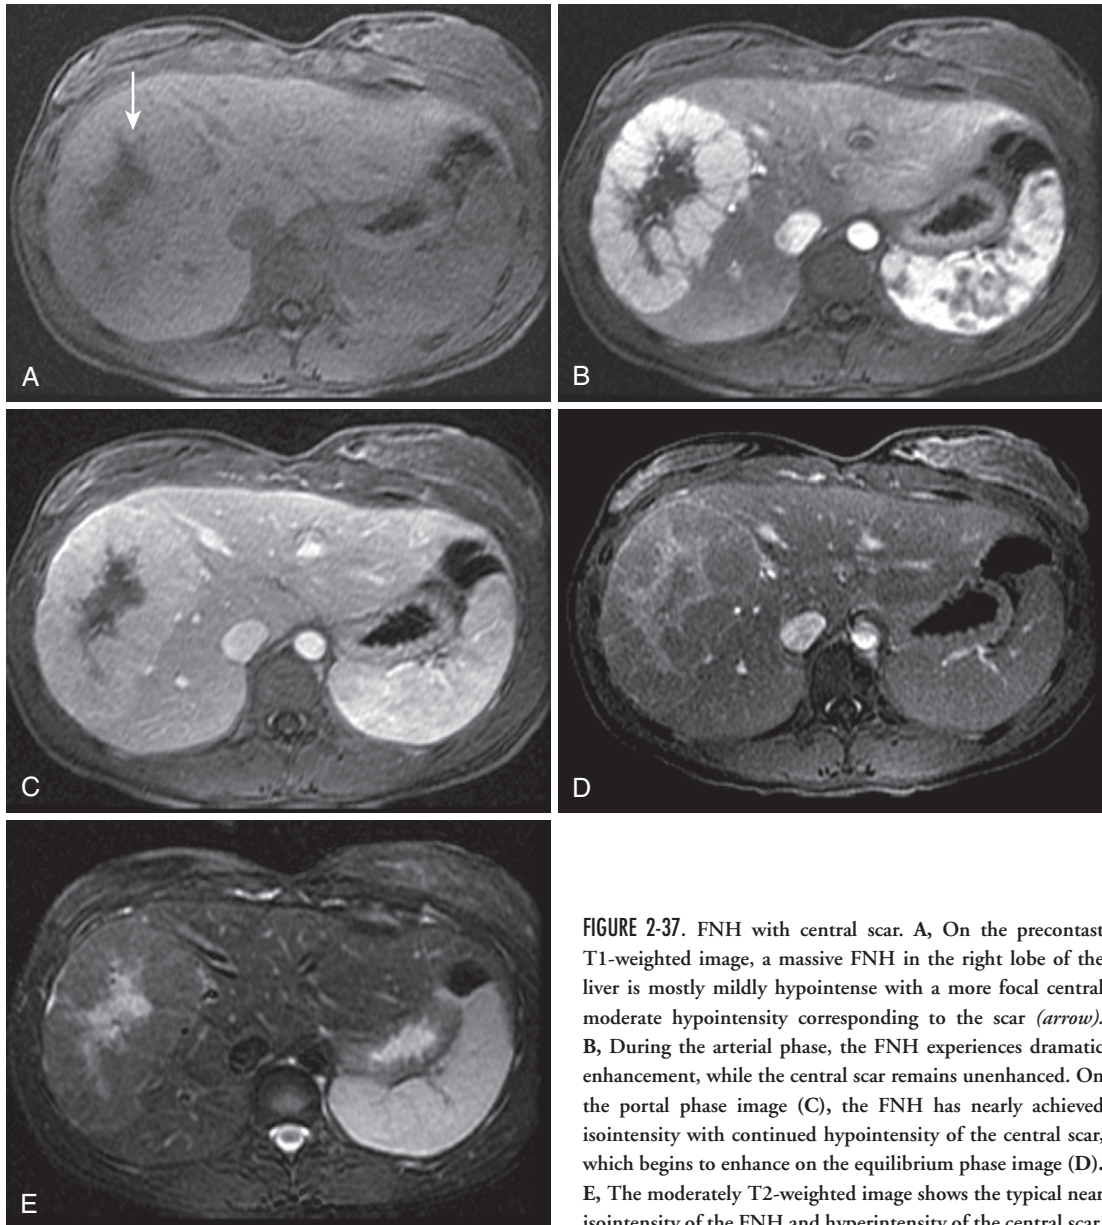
FNH with central scar. A, On the precontrast T1-weighted image, a massive FNH in the right lobe of the liver is mostly mildly hypointense with a more focal central moderate hypointensity corresponding to the scar (*arrow*). B, During the arterial phase, the FNH experiences dramatic enhancement, while the central scar remains unenhanced. On the portal phase image (C), the FNH has nearly achieved isointensity with continued hypointensity of the central scar, which begins to enhance on the equilibrium phase image (D). E, The moderately T2-weighted image shows the typical near isointensity of the FNH and hyperintensity of the central scar.
